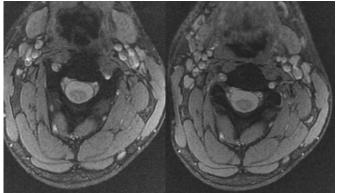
Cervical MRI performed 1 month after traumatism, axial sequences at C5-C6 level, showing presence of blod flow in V2 segment of right VA
